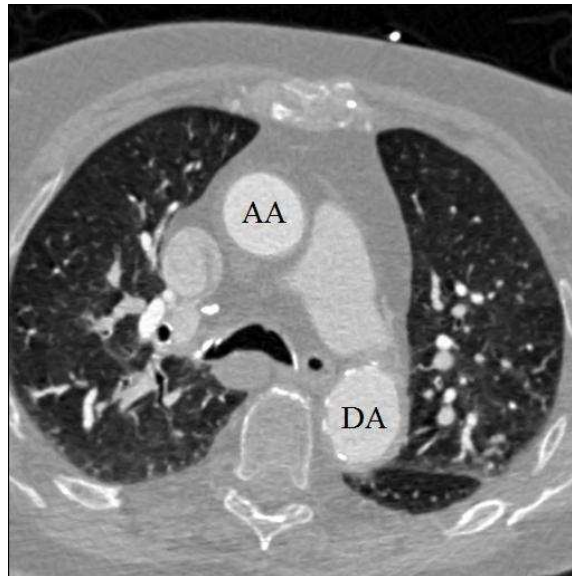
Top slice of a CT image. AA = Ascending Aorta, DA = Descending Aorta
